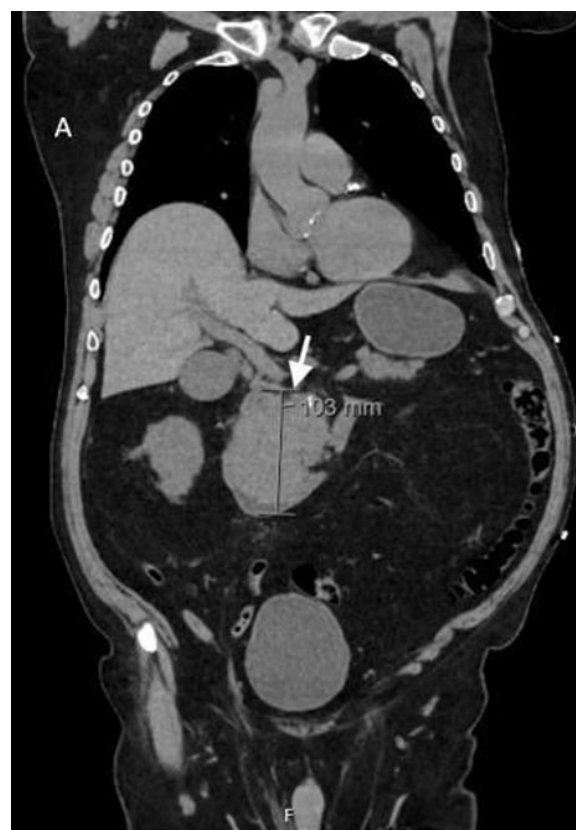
Coronal section of contrast enhanced computed tomography abdomen with arrow showing a large lobulated mass arising from the pancreatic head and uncinate process, measuring $10.2 \times 7.9 \times 10.3$ cm.
